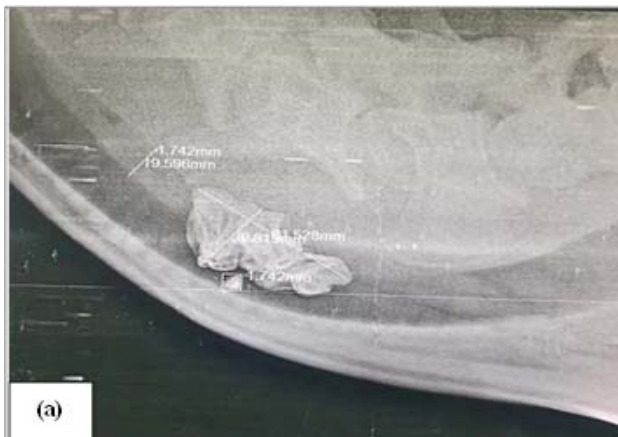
a) Left lateral mid-cervical radiograph showing presence of a soft tissue mass (leather) radiopaque foreign body within the esophageal lumen in Case 1.
